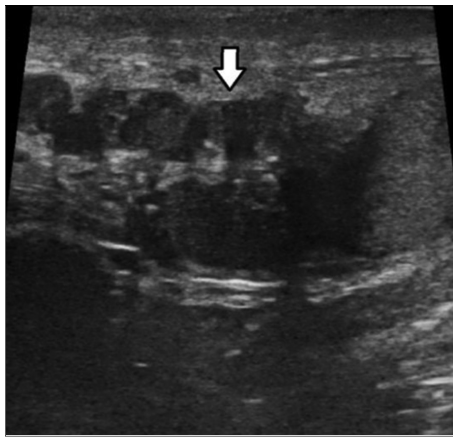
Ultrasound scan showing dilated and tortuous venous structures.
